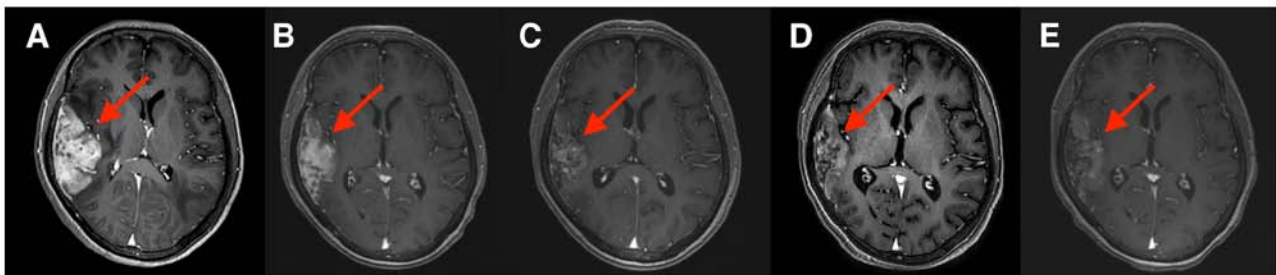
Brain MRIs of response of metastasis of right temporooccipital parietal lobe to apatinib + trastuzumab + albumin-bound paclitaxel. (A) Prior to combination treatment (T1-weighted enhancement), (B) after 2 cycles of combination treatment (T1-weighted BRAVO enhancement), (C) after 4 cycles of combination treatment (T1-weighted BRAVO enhancement), (D) after 6 cycles of combination treatment (T1-weighted enhancement) and (E) after 8 cycles of combination treatment (T1-weighted BRAVO enhancement). The white areas indicated by arrows are right temporooccipital parietal lobe metastases. MRI, magnetic resonance imaging. BRAVO, brain volume imaging.
